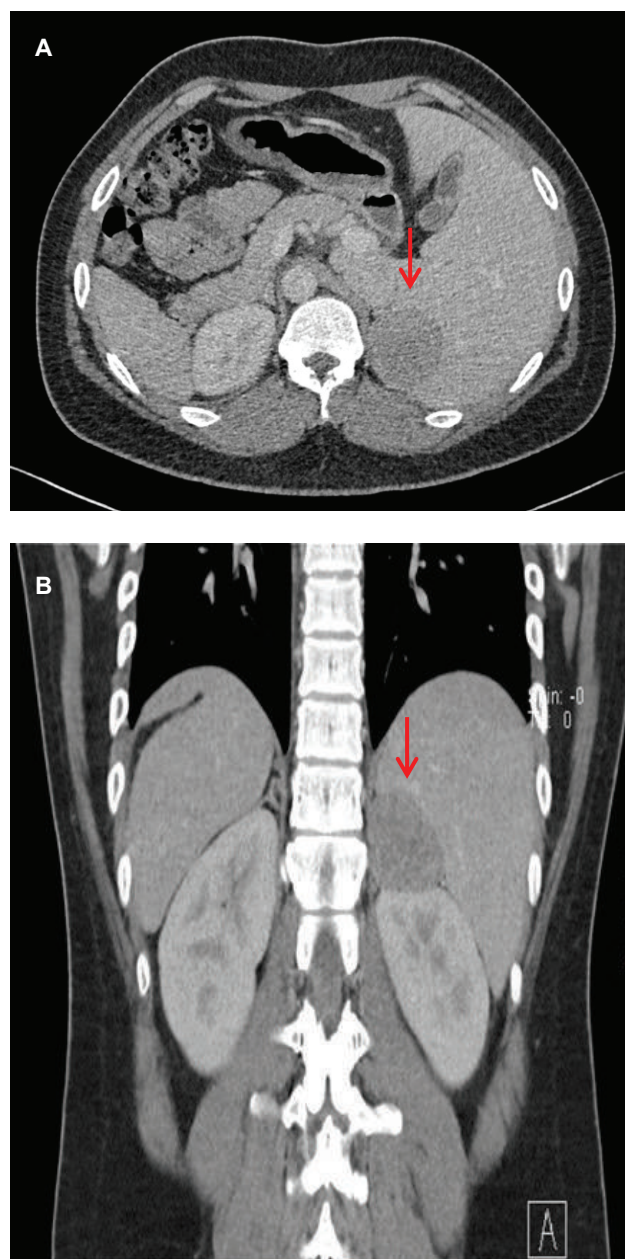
Computed tomography scans taken during the adrenal/venous phase (60 seconds after contrast injection). A well-defined, enhancing hypodense focus measuring 4.7 x 4.1 x 4.8 cm is seen in the left suprarenal region. (A) Axial view (B) Coronal view.
